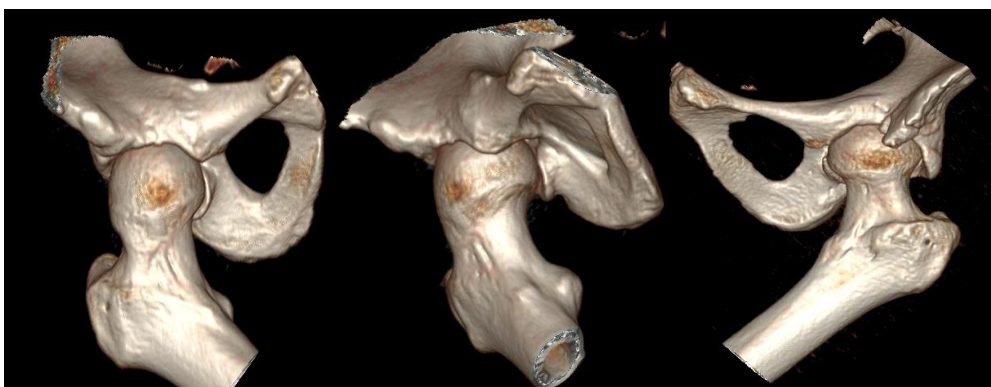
3D CT images of the hip from different angles
